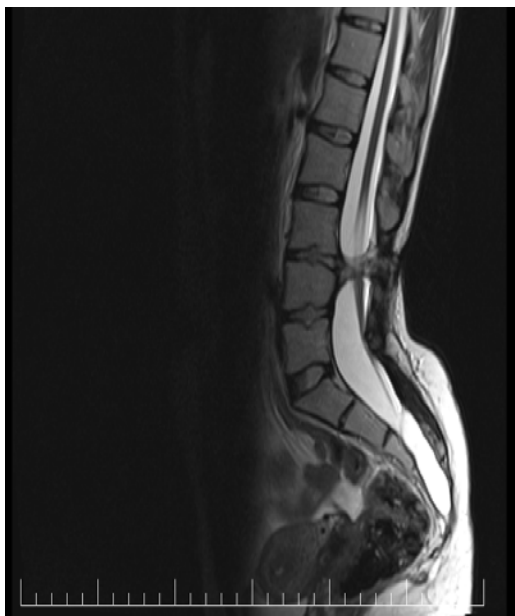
Lumbar spine MRI in sagittal plane showing the cartilaginous spur at L3-L4 level and tethered cord (conus medullaris at L4 level)
